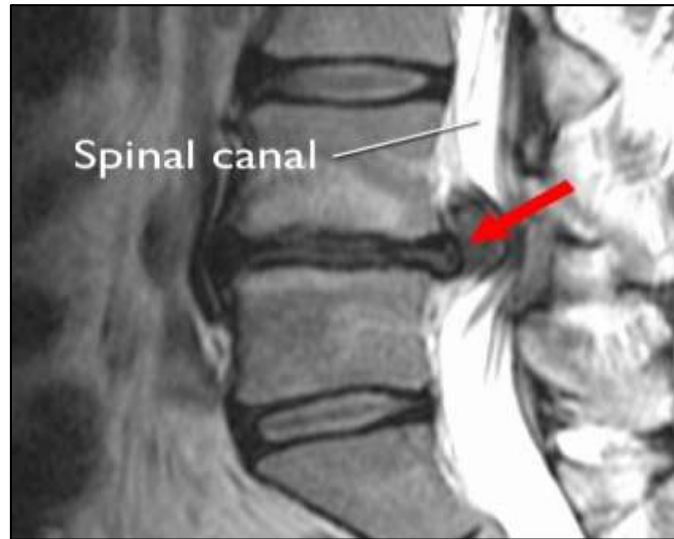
Sagittal T2 weighted MRI scan shows a herniated disk in the lower back (arrow). The disk is bulging out toward the spinal canal, putting pressure on the spinal cord and nerve roots(Deuk spine institute)
